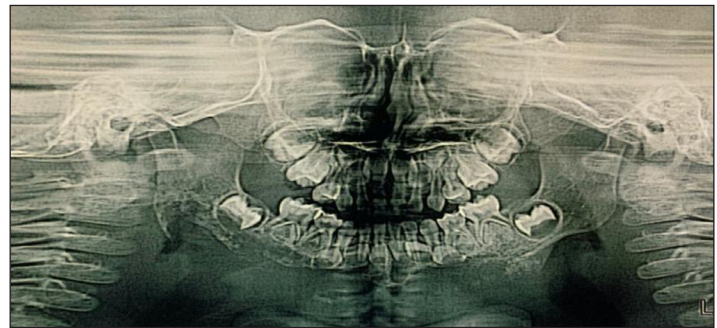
Panoramic radiograph showing osteolytic lesion from the right mandibular angle extending up to left mandibular body.
